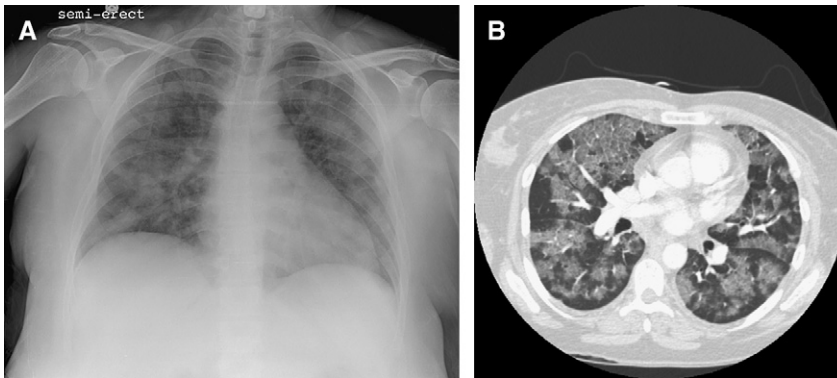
(A) Anterior-posterior chest radiograph in a 43-year-old woman recovering from knee surgery who developed respiratory distress and hypoxia during a PRBC transfusion. Bilateral pulmonary opacities are present. (B) Chest CT in the same patient revealing bilateral ground-glass opacities and interstitial septal thickening. CT was done 24 hours after the chest radiograph in Fig. 1A.
